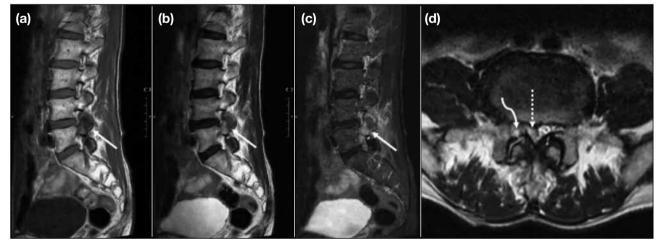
Magnetic resonance imaging of the lumbosacral spine of the patient. (a) T1-weighted sagittal image, (b) T2-weighted sagittal image, (c) T2-weighted short tau inversion recovery sagittal image, and (d) T2-weighted axial image at L4-L5 level. Abnormal bone marrow oedema in the right L4 inferior articular process and the right L5 superior articular process adjacent to the right L4/5 facet joint was shown (arrows in [a] to [c]). There was no significant joint effusion in the right facet joint. (d) Bony erosion of the right L5 superior articular process was noted (curved arrow). T2-weighted slightly hyperintense epidural lesion in the right lateral recess and the right subarticular region of the spinal canal at L4-L5 level was noted (dashed arrow), with compression on the thecal sac and the right L5 descending nerve.
